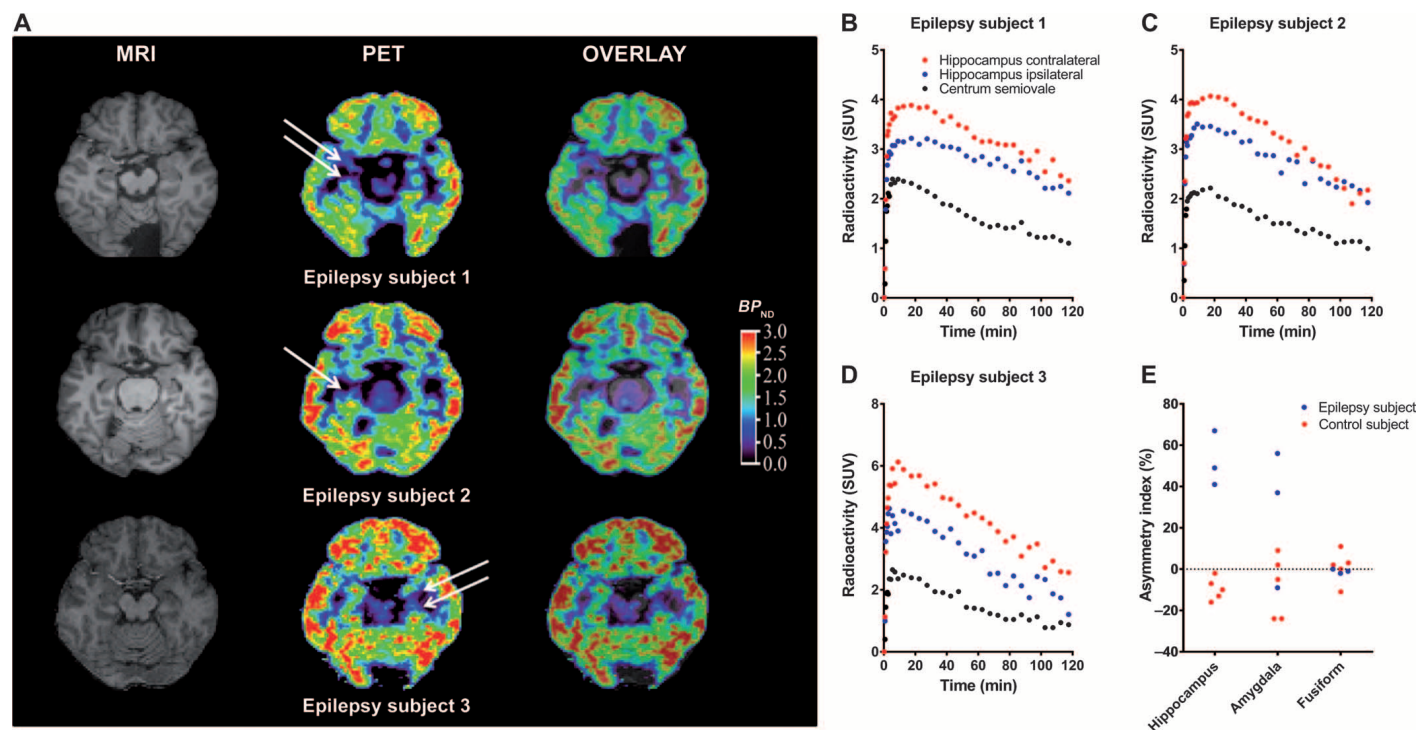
PET evaluation with $[^{11}C]UCB-J$ reveals unilateral mesial temporal sclerosis in epilepsy patients. (A) MR images, corresponding BP_{ND} maps of $[^{11}C]UCB-J$, and overlay in three TLE patients with unilateral mesial temporal sclerosis. The white arrows indicate loss of $[^{11}C]UCB-J$ binding in the mesial temporal lobe. (B to D) Regional TACs for radioactivity in hippocampus and centrum semiovale after intravenous injection of $[^{11}C]UCB-J$ in three epilepsy subjects. (E) Asymmetry indices between left and right hemispheres for healthy control subjects and between ipsilateral and contralateral hemispheres for epilepsy patients. Data are individual subjects, including original control subjects 1 to 5.
